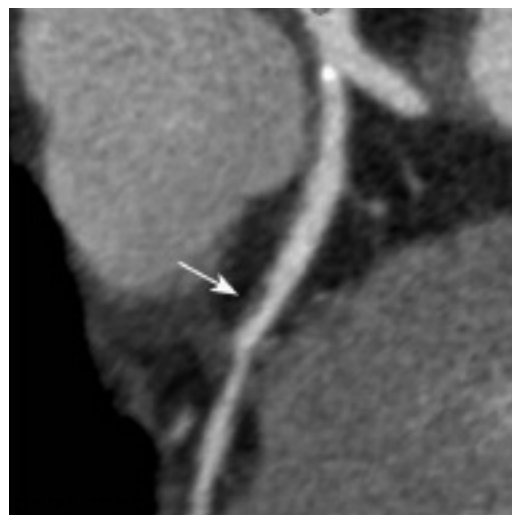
Multidetector computed tomography scan. Arrow indicates noncalcified plaque in a coronary artery.
